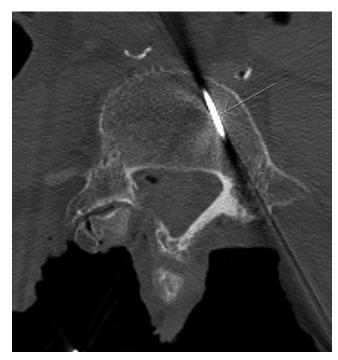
Axial CT scan of a Steinmann pin placed using the standard direct anterior trajectory.
